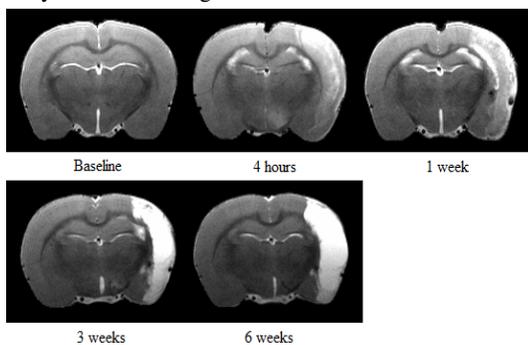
An example of T2-weighted images at multiple time points (baseline; 4 hours; and 1, 3, 6 weeks) after ischemia.
